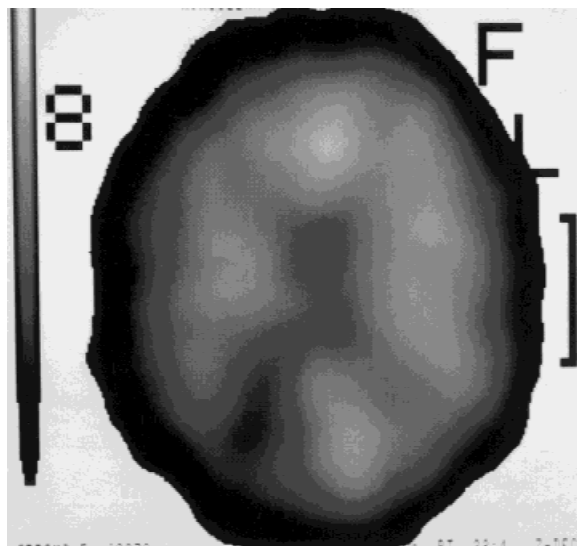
Case 2. SPECT study of  $^{99m}\text{Tc}$ -HMPAO uptake showing marked hypoperfusion in the right occipital region.
